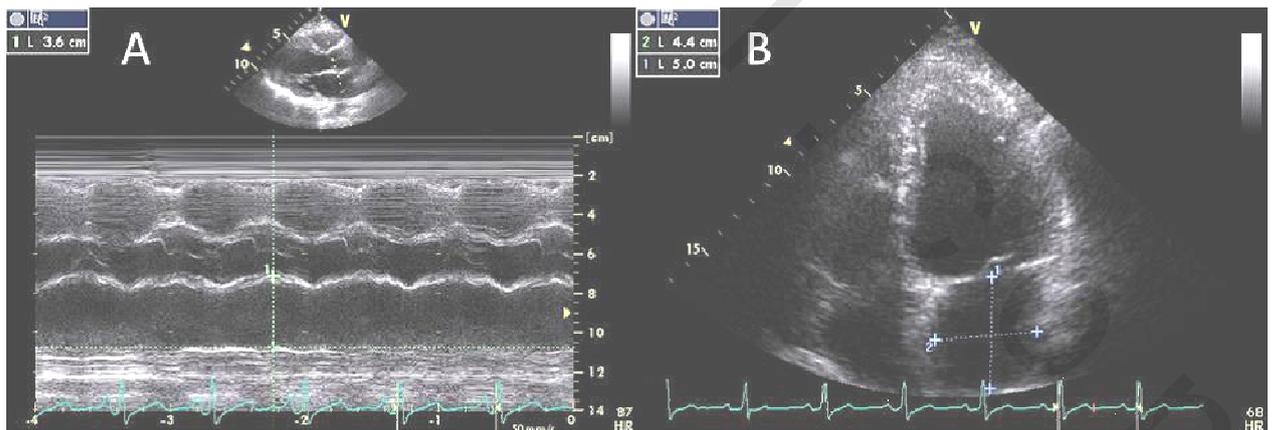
LA dimensions ⁽¹⁷¹⁾: antero-posterior diameter in parasternal long-axis view (A); longitudinal and transverse diameters in 4-chamber view (B).
